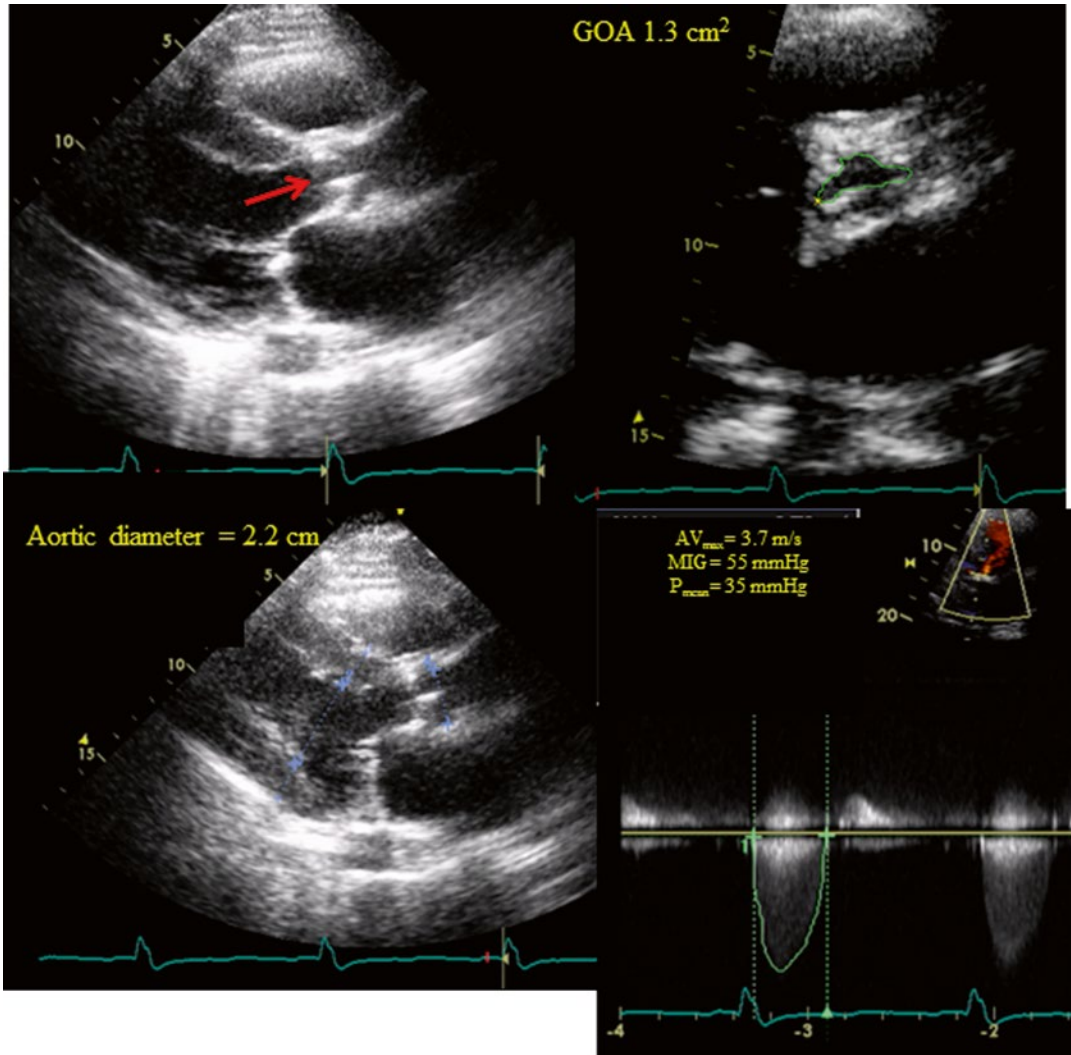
Case 3: Pressure recovery: significant pressure recovery in a patient with moderate aortic stenosis and small aortic diameter (Doppler-only reverse area/gradient mismatch). 80 year/old female with a history of an undetermined degree of aortic stenosis presents for TAVR evaluation. Echocardiography: AV_{vel} : 3.5 m/s, ΔP_{mean} : 30 mmHg, ΔP_{MIG} : 50 mmHg (*bottom right*), Dimensionless index (VTI): 0.16, EOADop (VTI): 0.6 cm², iEOA: 0.33 cm²/m², GOA by planimetry is 1.3 cm² (top right), aortic diameter: 2.2 cm (*bottom left*), $ELCo = (3.79 * 0.6 / 3.79 - 0.6) = 0.715$, noninvasive
